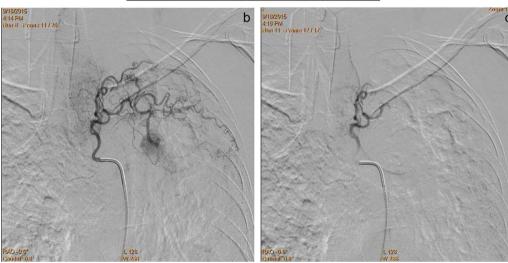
(a) CT scan image of a patient who presented with massive hemoptysis showing left upper lobar cavity with fungal ball. (b) DSA done before BAE showed hypertrophied left common intercostal trunk (giving rise to second and third intercostal arteries) with abnormal tortuous branches and a prominent vessel showing focal blush in the region of cavity probably indicating active extravasation. (c) Post BAE DSA showing complete disappearance of abnormal vascular blush.
